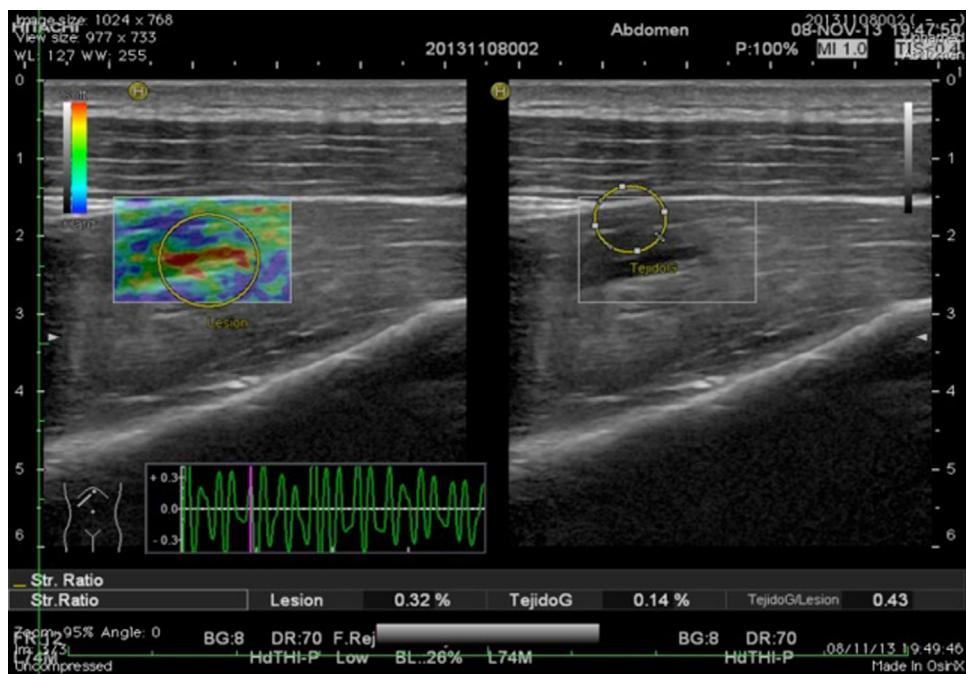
A hypoechoic elongated image at the supraspinatus muscle assessed with strain (compression) elastography and showing reduced stiffness (softer = red) compared with the surrounding normal tissue. A traumatic muscle tear was suspected as Doppler imaging ruled out the presence of any blood vessel. (Color version of figure is available online.)
